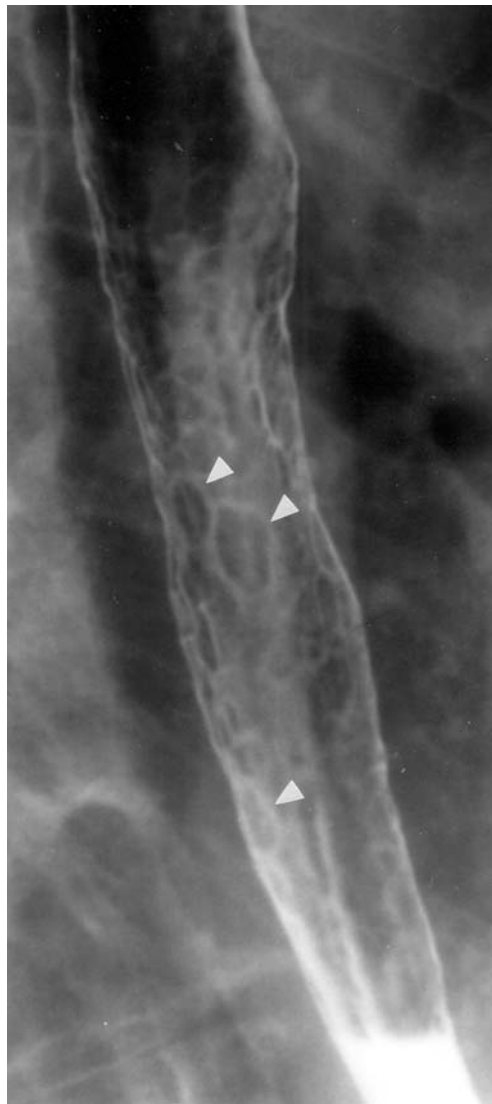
Reflux esophagitis with pseudomembranes. There are multiple discrete plaquelike lesions (arrowheads) representing pseudomembranes and exudates associated with severe reflux esophagitis. The plaquelike lesions of *Candida* esophagitis could produce similar radiographic findings
